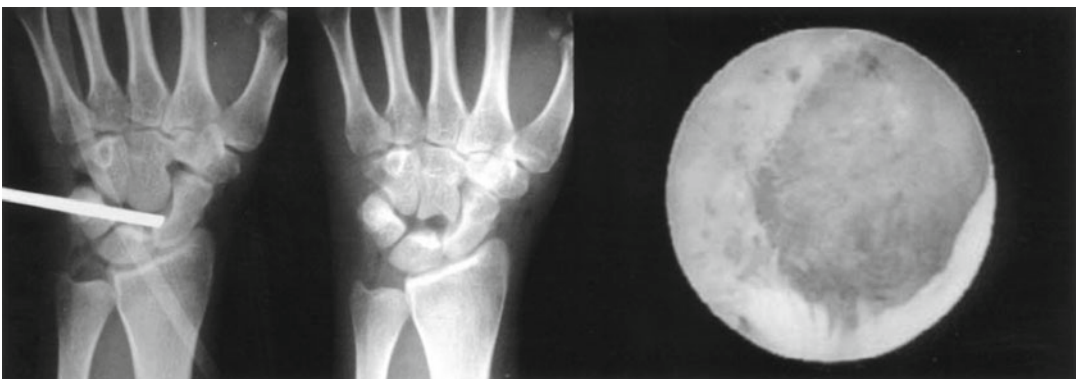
Radiograph of the arthroscope in the midcarpal joint and after arthroscopic resection of the head of the capitate. Republished with permission of Arthroscopy Association of North America and Elsevier, from Leblebicioğlu G, Doral
